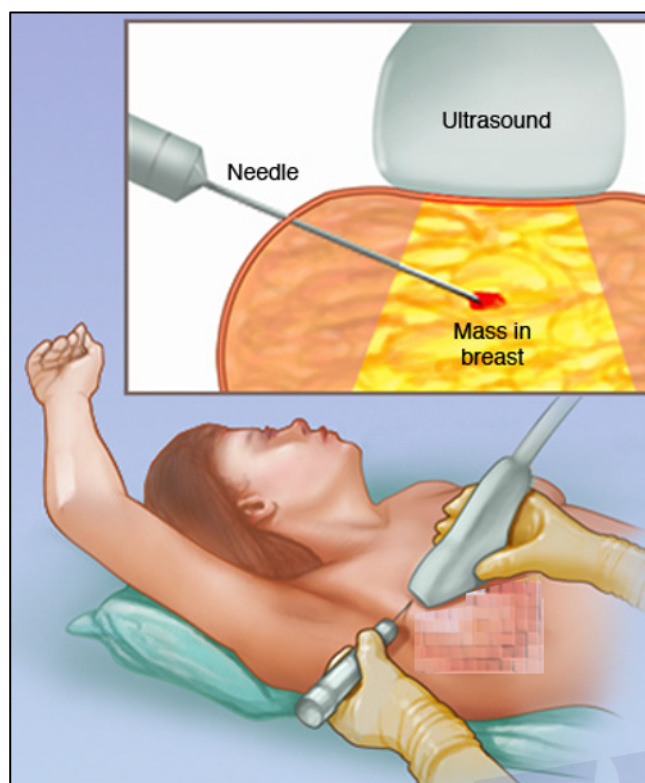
Ultrasound-guided core needle biopsy (Mayo Clinic, 2014)
